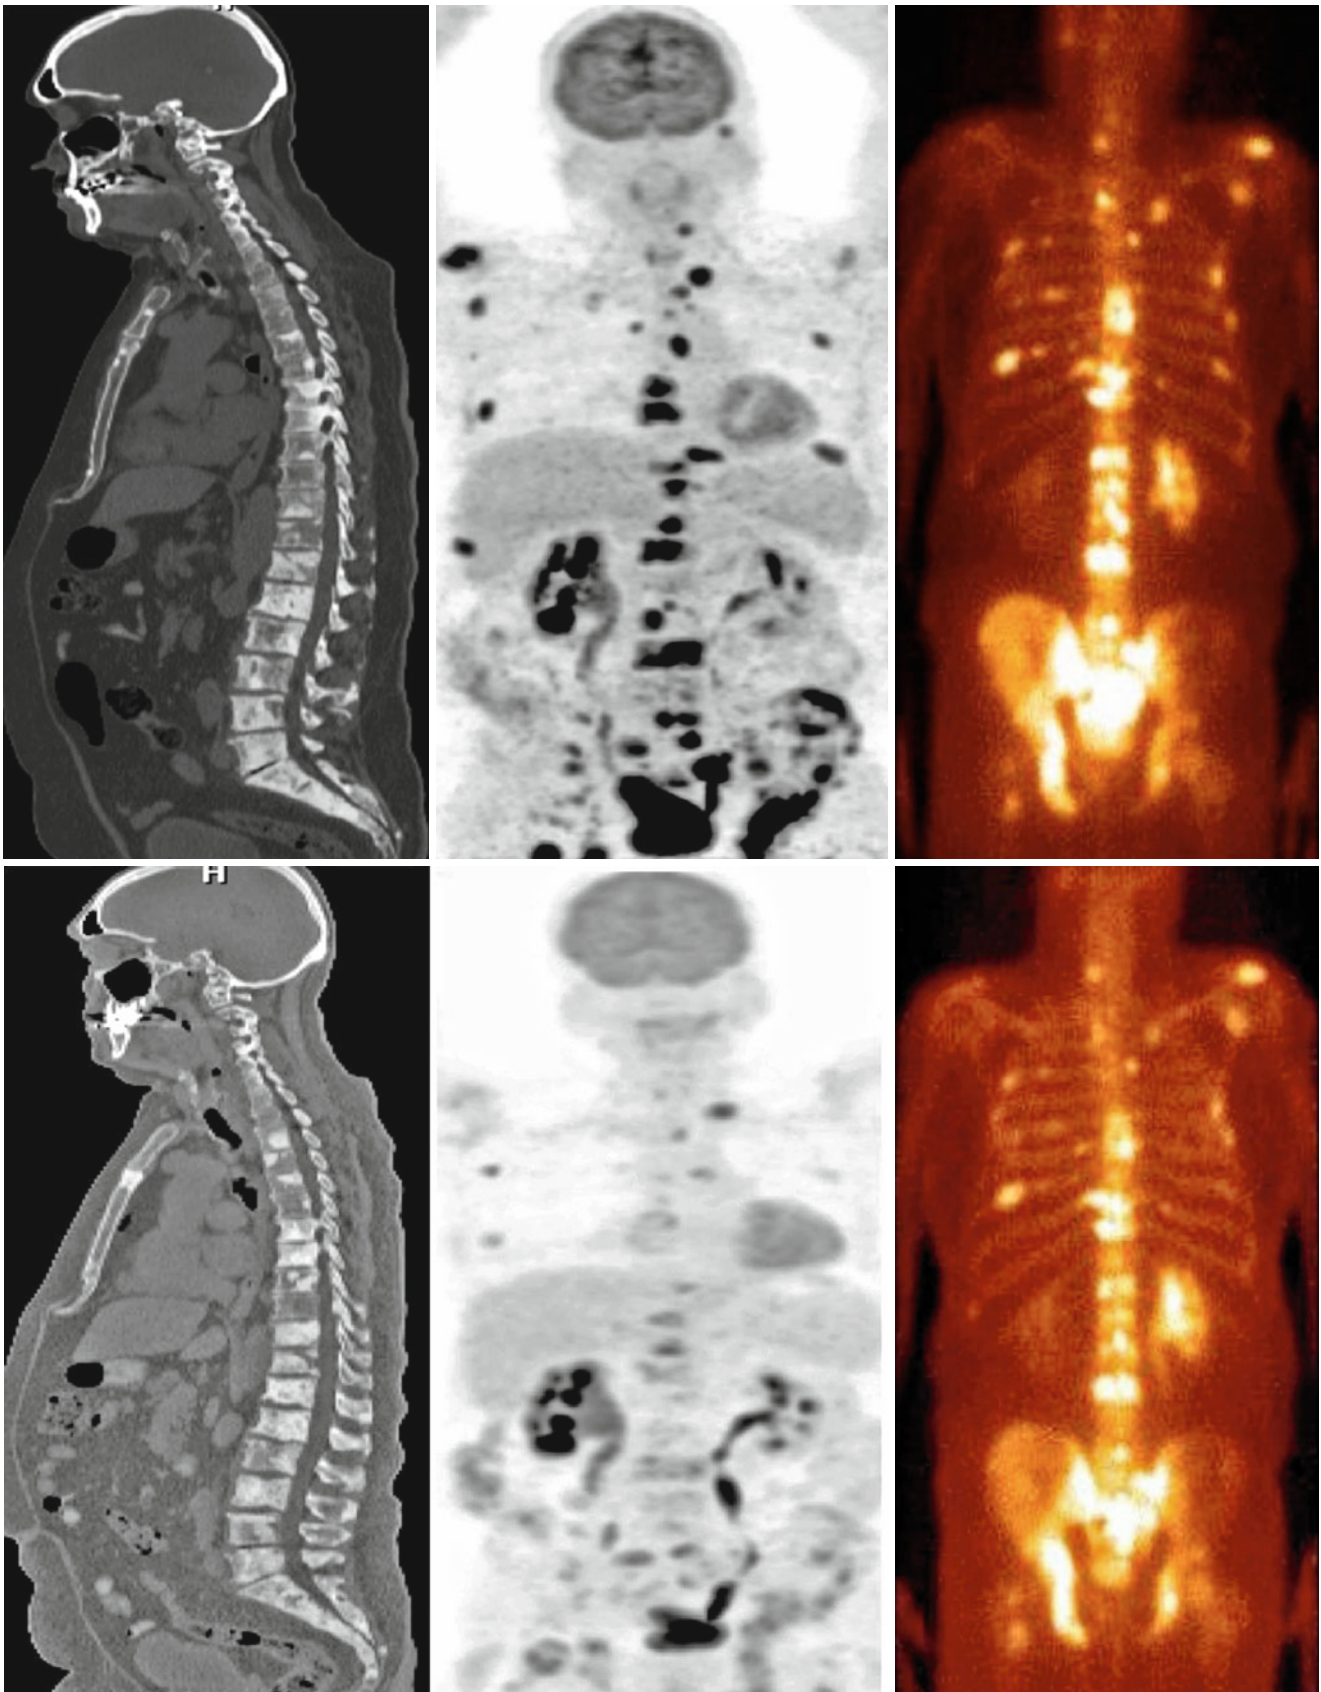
Midsagittal CT scan at bone window level (*left*), ^{18}F -FDG PET scan (*middle*), and $^{99\text{m}}\text{Tc}$ -methylene diphosphonate bone scan (*right*) images of a 63-year-old man with castrate-resistant metastatic prostate cancer before (*top row*) and after chemotherapy (*bottom row*). Note that ^{18}F -FDG PET best demonstrates the favorable response to
